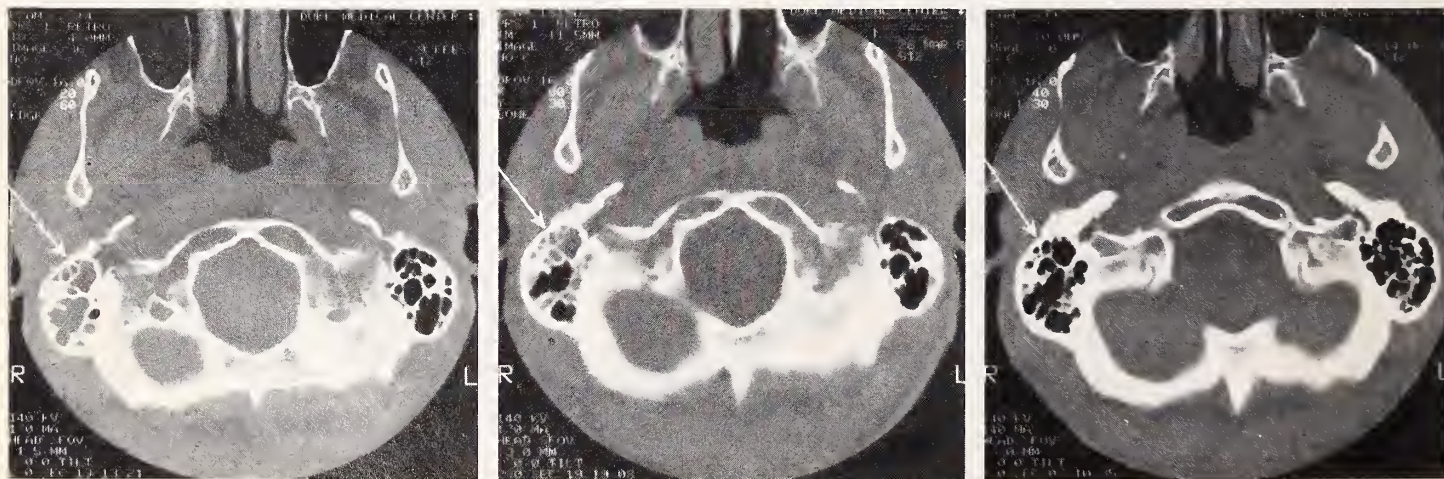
Computed tomographic scans showing (at arrows): (A) opacification of right mastoid sinus air cells at diagnosis (left); (B) partial clearing at end of intravenous antibiotic therapy (middle); (C) full resolution six weeks after stopping antibiotics (right).
